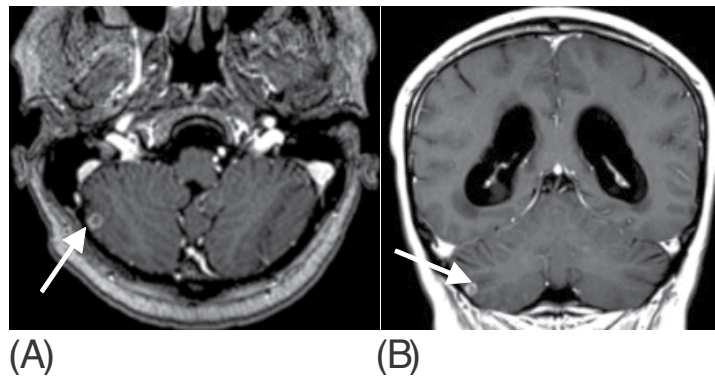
Cranio-cerebral MR images showing cerebellous tuberculoma in a 41 year-old patient with a 5 year history of HIV infection nonadherent to the antiretroviral treatment. The patient was admitted with a cerebellous tuberculoma and acute ischemic stroke. The laboratory data on admission disclosed a CD4 count of 145 cells/mm³ and RNA HIV load 240000 copies/ml. Axial T1 weighted images shows (A): Focal enhancing triangular lesion in the anterolateral right-side of the pons of 5x9 mm with FLAIR hyperintensity, diffusion restriction, no significant changes in the apparent diffusion coefficient (ADC) and no contrast enhancement (the aspect is suggestive for acute ischemia); a right focal cortico-subcortical cerebellous lesion with peripheral ring enhancement on T1 weighted images and mass effect (the aspect is compatible with a tuberculoma). Coronal T1 weighted images shows (B): symmetrical enlargement of the ventricular system with no midline shift; transependymal circumferential resorption edema is present adjacent to the ventricular wall; no intraventricular obstruction or contrast enhancement. *Conclusions:* acute ischemic stroke in the anterolateral right side of the pons; focal anterolateral parenchymal lesion suggestive for a tuberculoma; significant hydrocephalus with no intraventricular obstruction.
